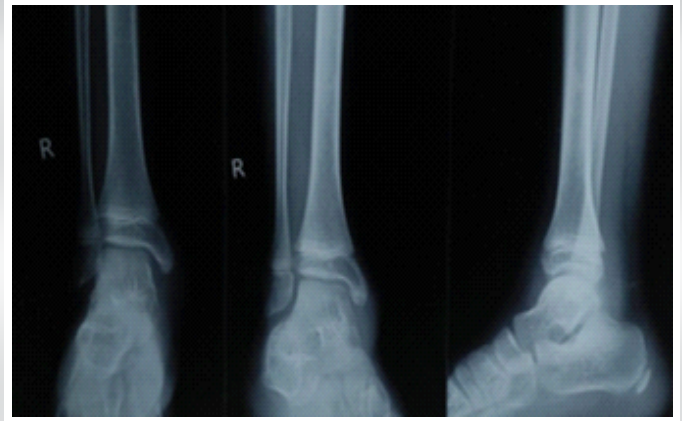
X-ray radiograph of right ankle of patient shows normal study.
